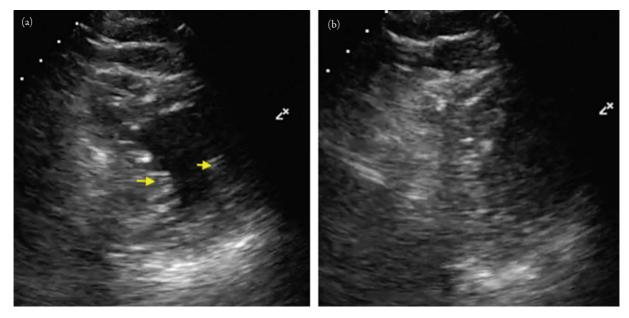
Parasternal short axis at mid apex, at end diastole (a) and end systole (b).
